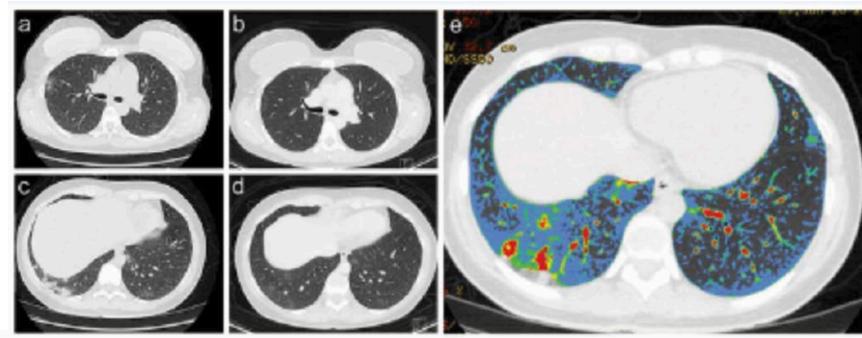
CT chest scans performed on the 11th day of symptoms (a, c and e) and 24th day of symptoms (b and d) of the second clinical episode. (a) and (c) Ground-glass opacities associated with bilateral and multilobar consolidation foci, predominantly peripheral, sometimes with a rounded aspect, some with areas of septal thickening, more evident in the lower right lobe. (b) and (d) Almost complete resolution of the alterations found in the previous exam, with discrete areas of attenuation in ground glass persisting. (e) Graphical demonstration with color map overlay. The areas in blue represent mild impairment, in green a little greater impairment, in yellow greater impairment and in red consolidations.
